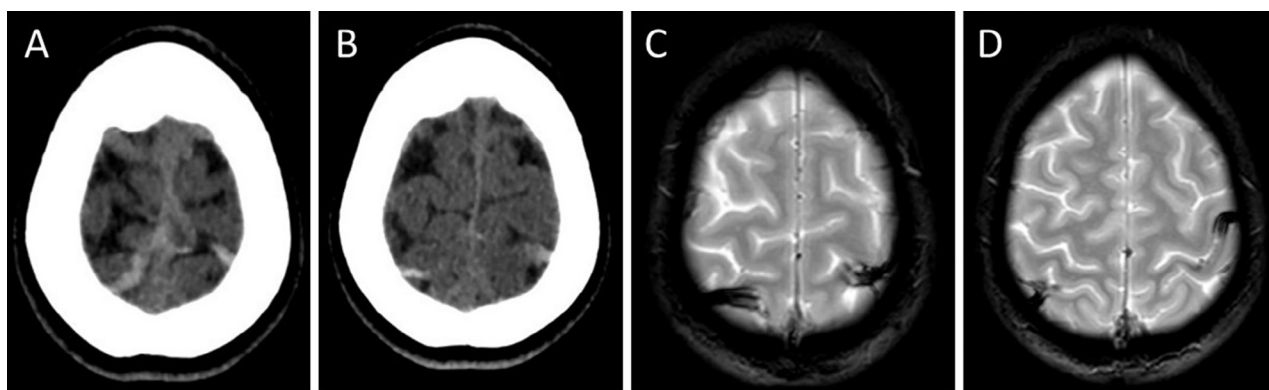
(A and B): Unenhanced brain CT showing bilateral cortical hyperdensities, most likely thrombosis of cortical veins. (C and D): T2* weighted MRI sequences showing bilateral cortical vein thrombosis in the parietal region. Abbreviations: CT, computed tomography; MRI, magnetic resonance imaging.
